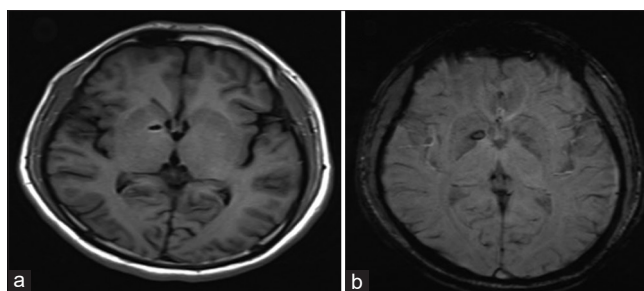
a,b: T1W MRI Brain and Susceptibility weighted image (SWI) image showing small right basal ganglia hemorrhage
